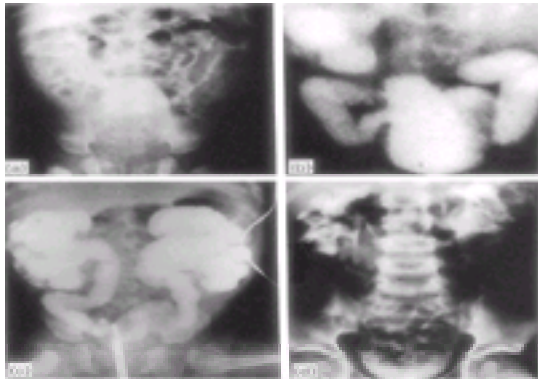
Radiographs of 2-month-old infant with severe urethral valves, uremia, and acidosis, treated by resection of valves and immediate reconstruction 1 week after admission to the hospital. (a) Intravenous pyelogram before admission showing poor visualization bilaterally. (b) Cystogram with massive bilateral reflux and hydronephrosis. If valves are likely, a cystogram should be done first because if reflux is present the upper tracts will be visualized, obviating the need for an intravenous pyelogram. (c) Retrograde pyelogram taken at time of reconstructive procedure. The baby was first treated with drainage of the bladder through a small plastic catheter *per urethra*, intravenous fluid, bicarbonate, and antibiotics, which greatly improved his clinical state. At endoscopy, ureteral orifices were massively dilated. It was believed that with massive reflux and this degree of hydronephrosis it would be safest to repair the ureters rather than wait. (d) Intravenous pyelogram age 6 years. This patient is now aged 27 years. He is 6ft 4in tall, weighs 200 pounds and has a stable intravenous pyelogram. The serum blood urea nitrogen is 9 mg/100, and serum creatinine 1.4 mg/100. Renal function is two-thirds of normal, measuring 66 l/m² body surface area.
